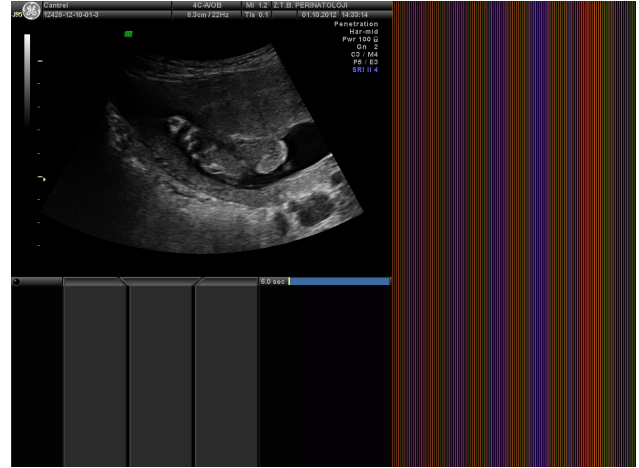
Fetal heart seen out of the thorax at the ultrasound examination
